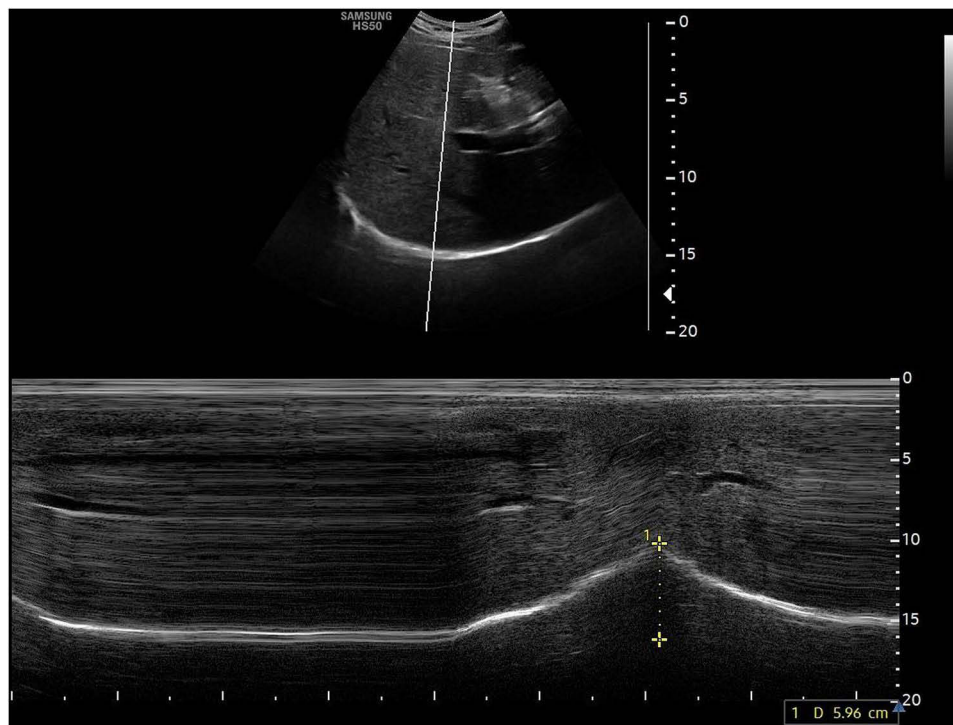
M-mode ultrasound assessment of hemidiaphragmatic excursion via a subcostal approach during deep breathing. After identifying the diaphragm in B-mode, M-mode was activated to record real-time diaphragmatic motion. Calipers were placed at the baseline (end-expiration) and at the peak of inspiration (I) to measure excursion in centimeters.
